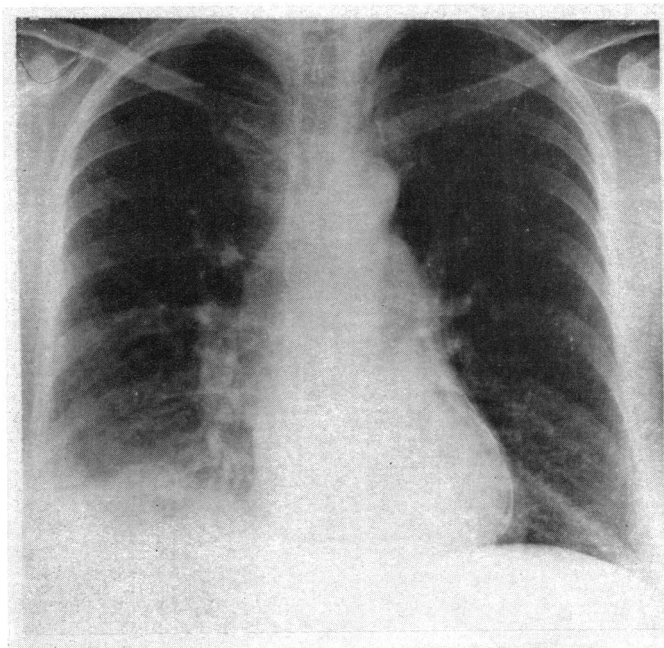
Chest radiograph showing a heart of normal size, a thin line of calcium round the ventricular border, and a right pleural effusion.
